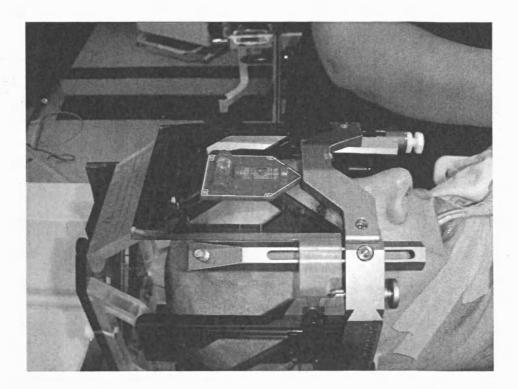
Leksell G frame in position in dystonic patient with fiducial box attached just prior to MRI scanning. Note the biaxial spirit level to check the frame is completely level in both planes.
